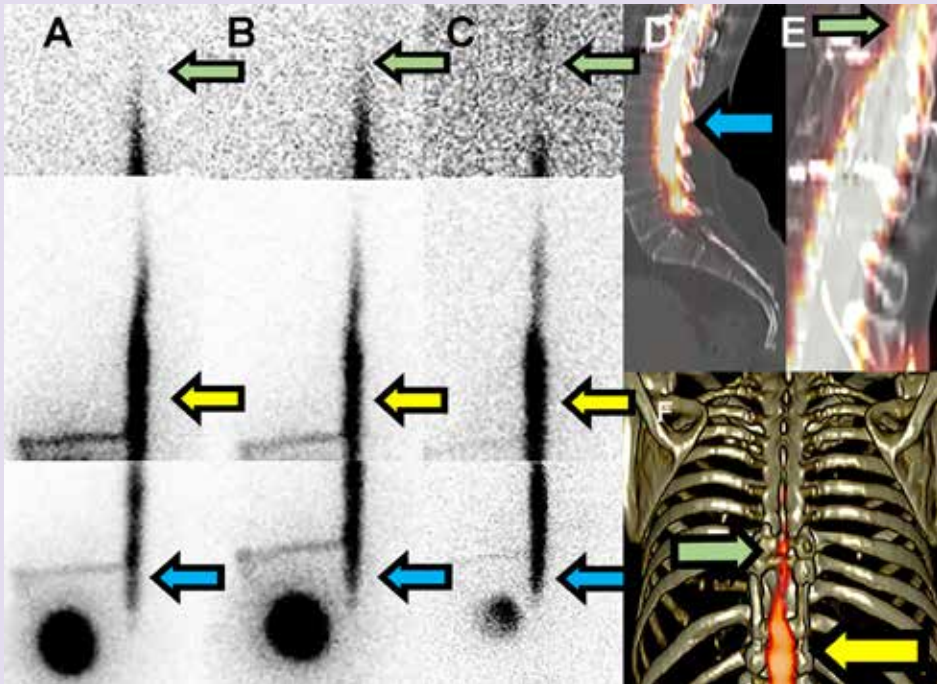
CSF flow obstruction in a 47-year-old female with spasticity with a spinal cord lesion at T10. Planar imaging at 48 h (A), 72 h (B) and 7 days after injection (C) revealed increased lumbar-caudal tracer activity (yellow and blue arrows) and tapering of tracer activity with reduced rostral tracer activity spread (green arrows) without tracer activity at the cerebral cisterns. SPECT-CT images (D,E) also showed increased tracer activity at the lumbar-caudal level (blue arrow) and tapering of tracer activity (green arrow). The 3D reconstruction image (F) clearly shows pronounced lumbar tracer activity (yellow arrow) and tapering of tracer activity (green arrow) more rostrally.
